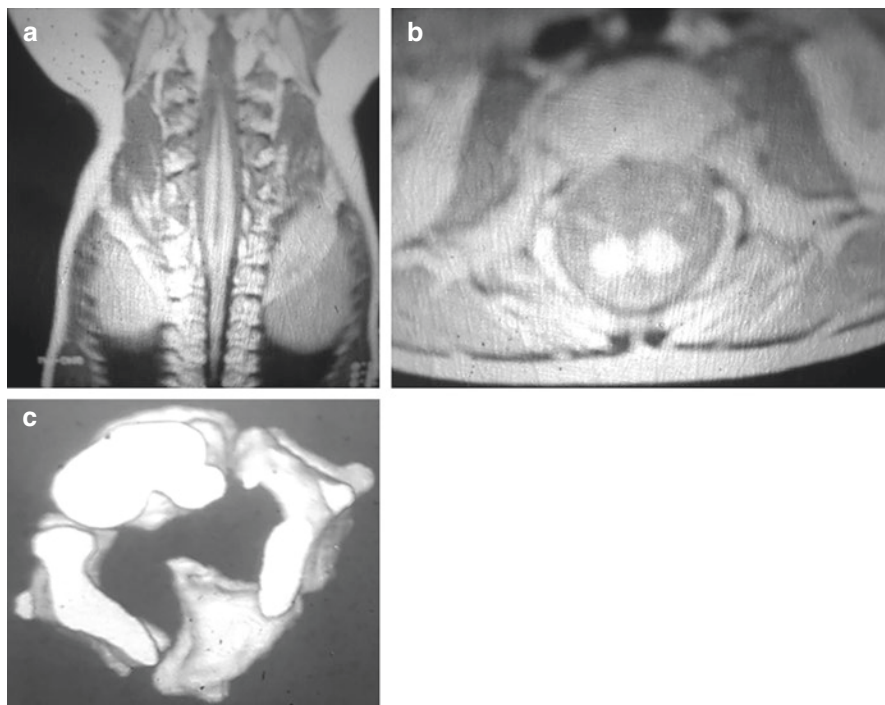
Type I split cord malformation. (a) Coronal and axial (b) MRI revealing the two hemisacs. (c) 3D Computed Tomography (CT) reconstruction scan revealing the bony spur. The patient was operated via a laminotomy. The bony spur was dissected extradurally between the two dural sacs and removed piecemeal
